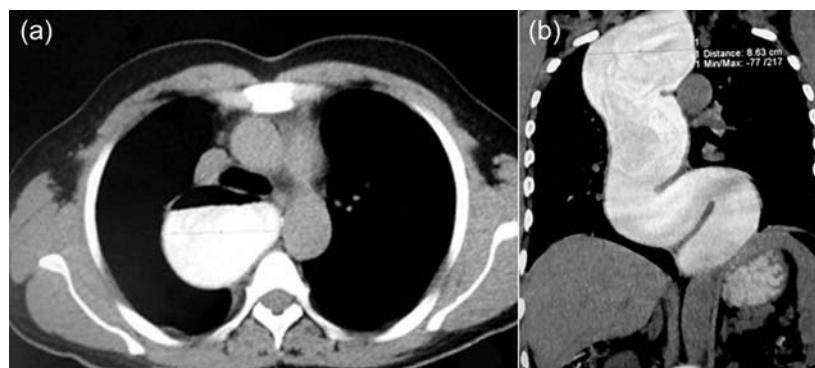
CT of chest showing (a) grossly dilated fluid-filled oesophagus compressing on the trachea and (b) sigmoid oesophagus, with a maximum diameter of 8.63 cm.
